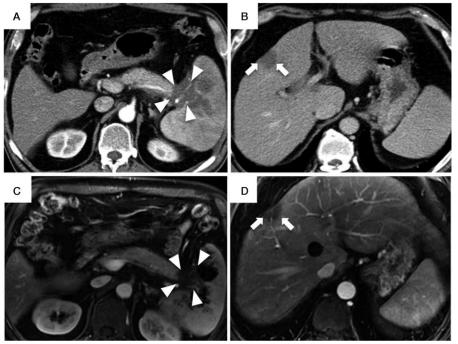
Image studies of the upper abdomen after neoadjuvant chemotherapy. An abdomen CT (panels A and B) and MRI (panels C and D) shows masses in the tail of pancreas (arrowhead) and in the left liver (arrow) shrank dramatically, findings suggestive of a good response to chemotherapy. CT = computed tomography.
